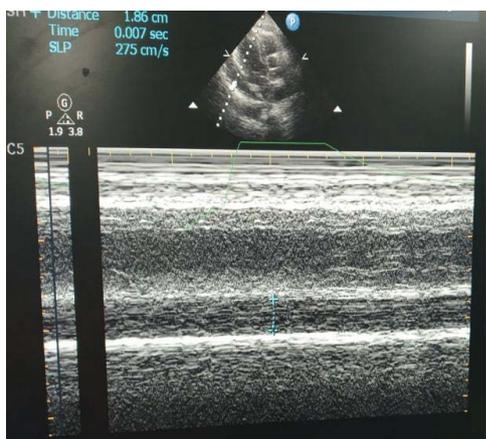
Echocardiographic image showing pericardial effusion and thickening.
